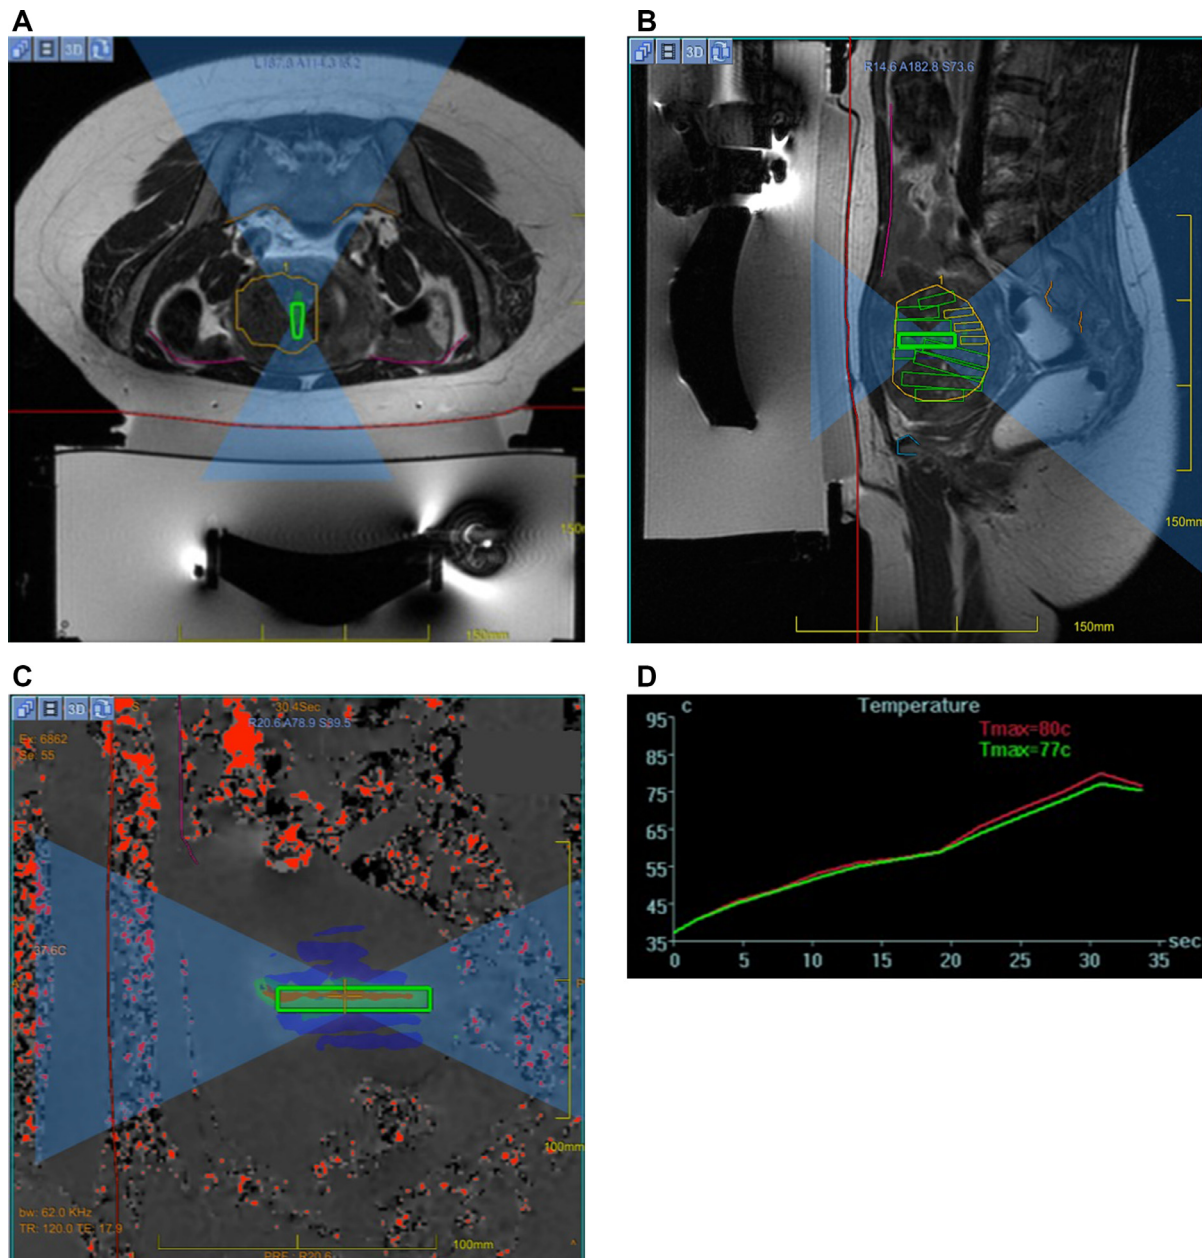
Axial (A) and Sagittal (B) MRI images acquired during the planning phase at the beginning of MRgFUS procedure. US beam representation is shown in light blue; the red line indicates the skin-gel pad interface; the orange line indicates the nonpass region marker along the surface of the sacrum, in order to avoid any potential neural injury to sacral nerves; the pink line indicates the nonpass region marker of bowel loops; the region of treatment is bordered by a yellow line. Once that all these regions are manually marked, the software automatically splits the region of treatment into many discrete sonications (green boxes): the operator can change automatic parameters in any time during the procedure. (C) Real-time thermometric map obtained at the end of a single sonication during the procedure using proton resonance frequency sequences; the red area within the sonication volume represents the site where the critical threshold for necrosis has been reached. (D) Temperature trend in treated area during the sonication time, measured in real-time. (Color version of figure is available online.)
